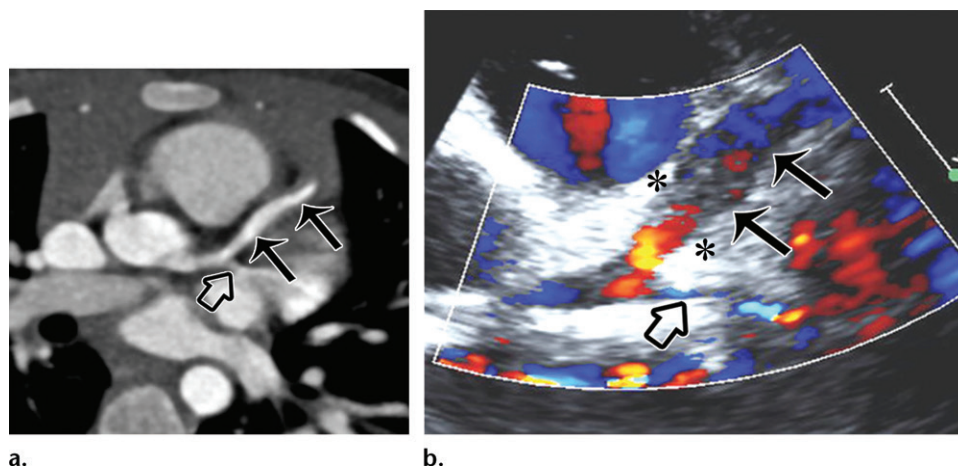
Fusiform aneurysmal dilatation in a 4-year-old boy with KD. Curved planar reformation (a) from coronary CT angiography along the LAD and color Doppler echocardiogram (b) show long-segment fusiform aneurysmal dilatation (solid black arrows) of the LAD, measuring 5 mm at its greatest internal diameter. Perivascular echogenicity (*) in (b) and the proximal LCx (open arrow) are also demonstrated.
